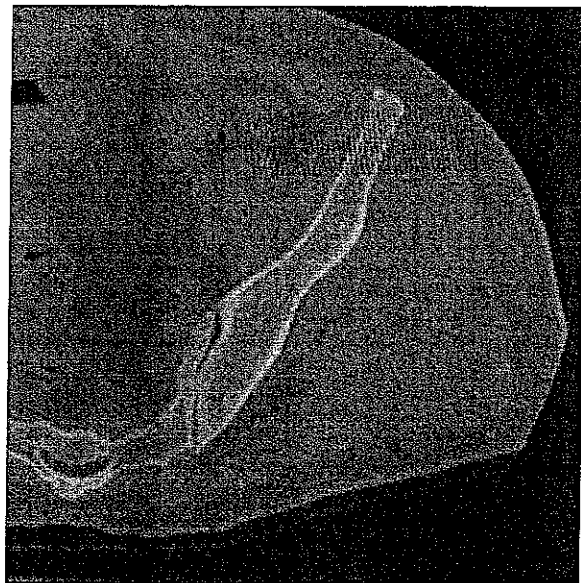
CT image with highlighted rectangular region corresponding to US image. During registration, the location of a given US image within the CT volume can be computed.
